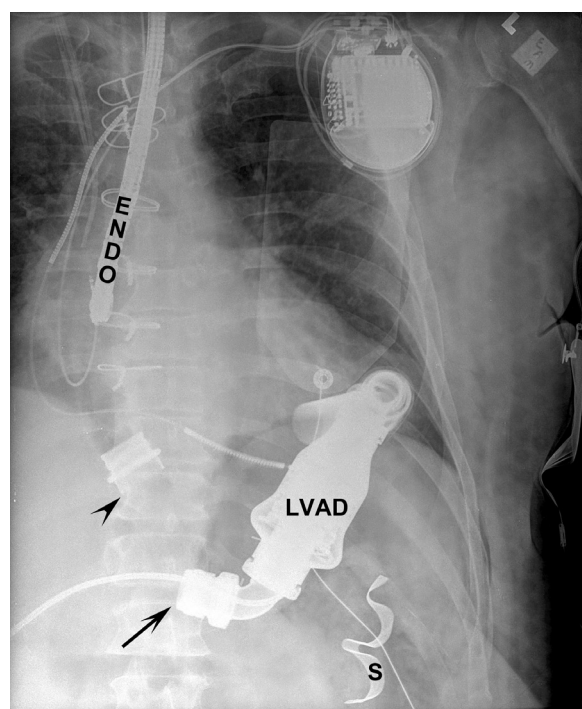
■ Anteroposterior (AP) supine chest x-ray, intraoperative. Detached left ventricular assist device (LVAD) outflow cannula (gap between arrowhead and arrow). Also, note an esophageal probe (ENDO) and a left upper quadrant surgical sponge (S).
